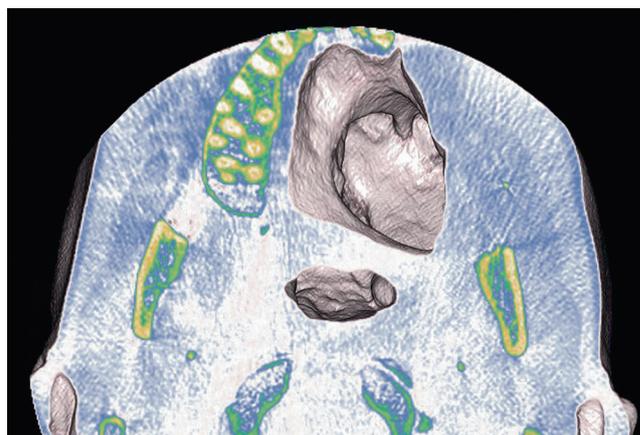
Cone beam computerized tomography rendering, inferior view of maxillectomy defect.
